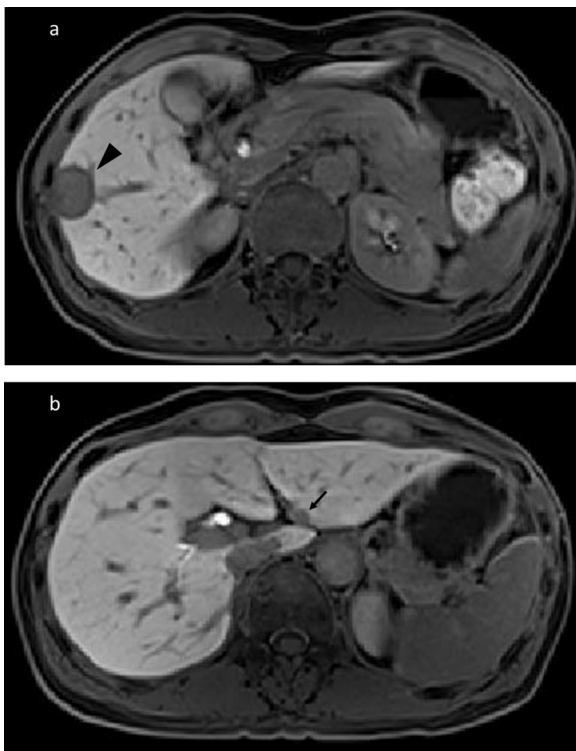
Dynamic magnetic resonance imaging of the liver showed (a) a peripherally enhanced 25-mm mass in segment V (black arrowhead) and (b) a peripherally enhanced 8-mm mass in segment II (arrow).
